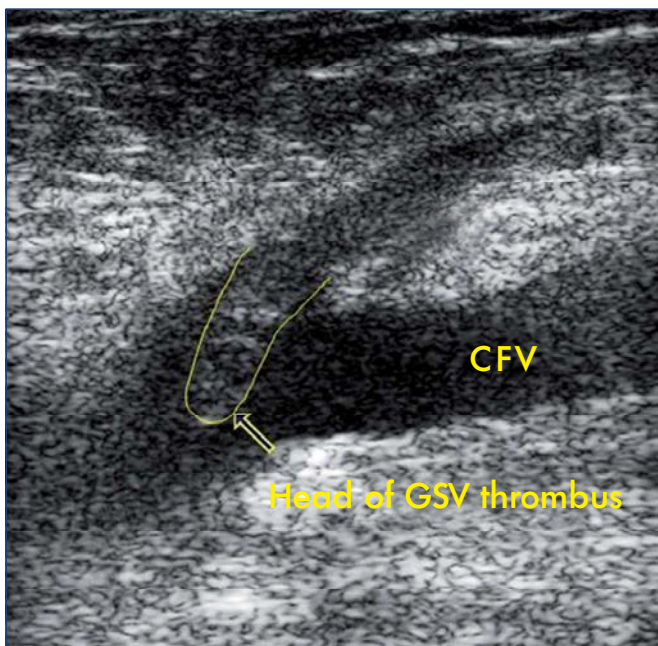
Ultrasound of an extension of a thrombosis of the great saphenous vein into the common femoral vein.
